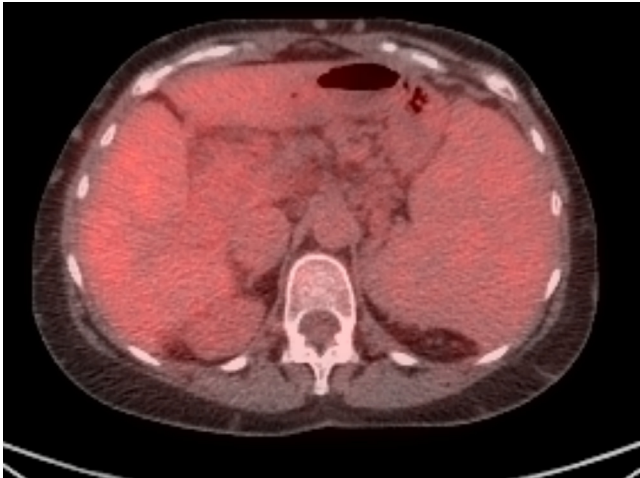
No significant ^{18}F -FDG uptake seen on ^{18}F -FDG PET-CT.
